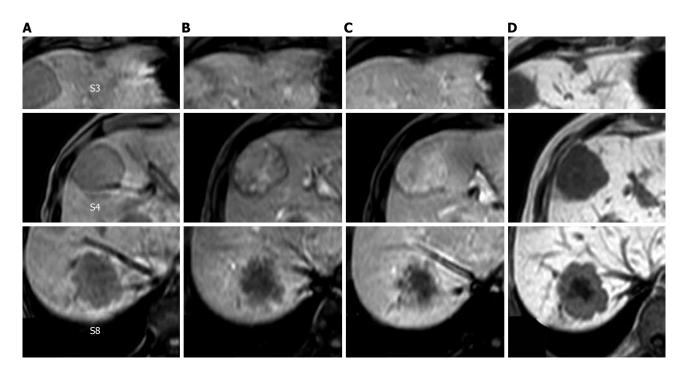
T1-weighted gadolinium ethoxybenzyl diethylenetriamine pentaacetic acid-enhanced magnetic resonance imaging. A: Pre-enhancement; B: 30 s; C: 120 s; D: Hepatocellular phase. The tumor in segment 4 showed heterogeneous enhancement in the dynamic phase. The tumors in segments 3 and 8 showed gradual peripheral enhancement.
